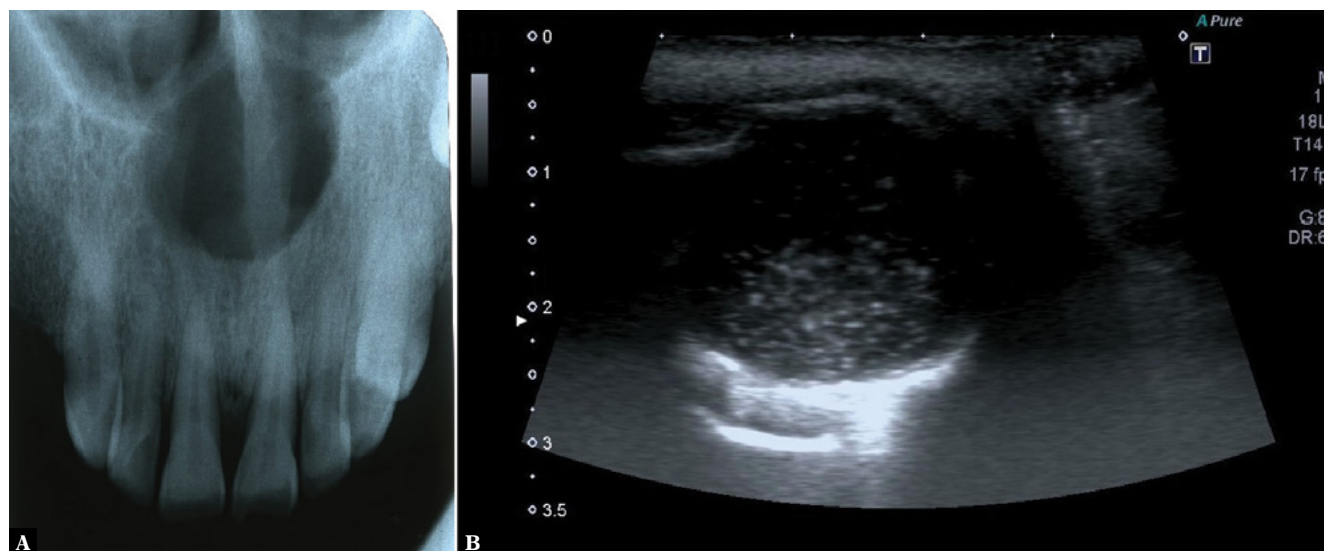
A. Occlusal radiographs show that well-defined radiolucent lesion in anterior maxilla. (incisive duct cyst) B. The snowflakes-like appearance of intraosseous lesions on ultrasonography (incisive duct cyst)
